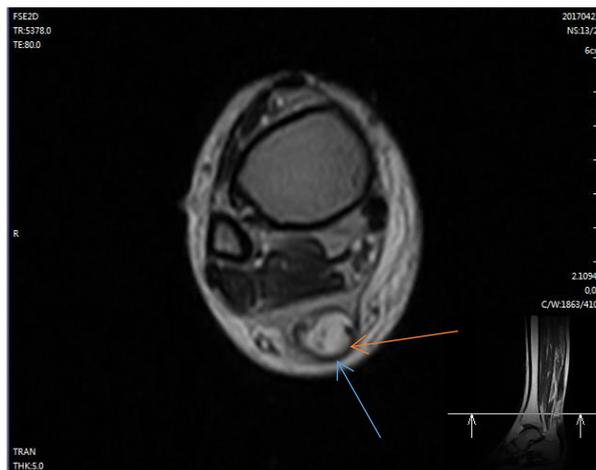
Axial T2W MRI image of the right lower extremity through the defect showing increased signal intensity due to edema. The plantaris tendon is however intact. (Red arrow).
